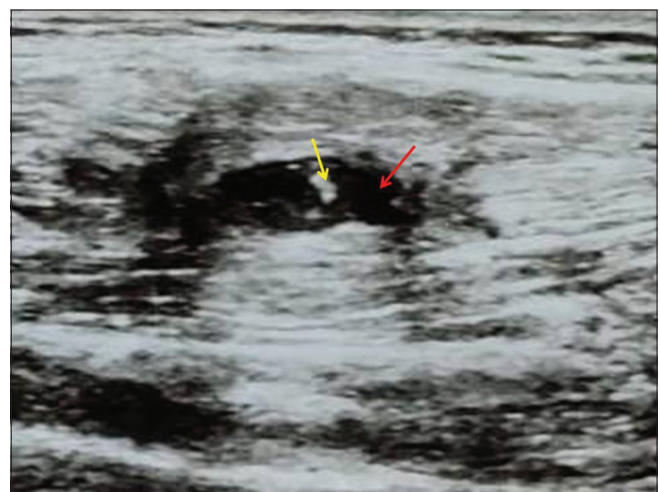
The ultrasonography of the right leg. The red arrow shows the hypoechoic cyst and the yellow arrow shows the hyperechoic scolex in the center
